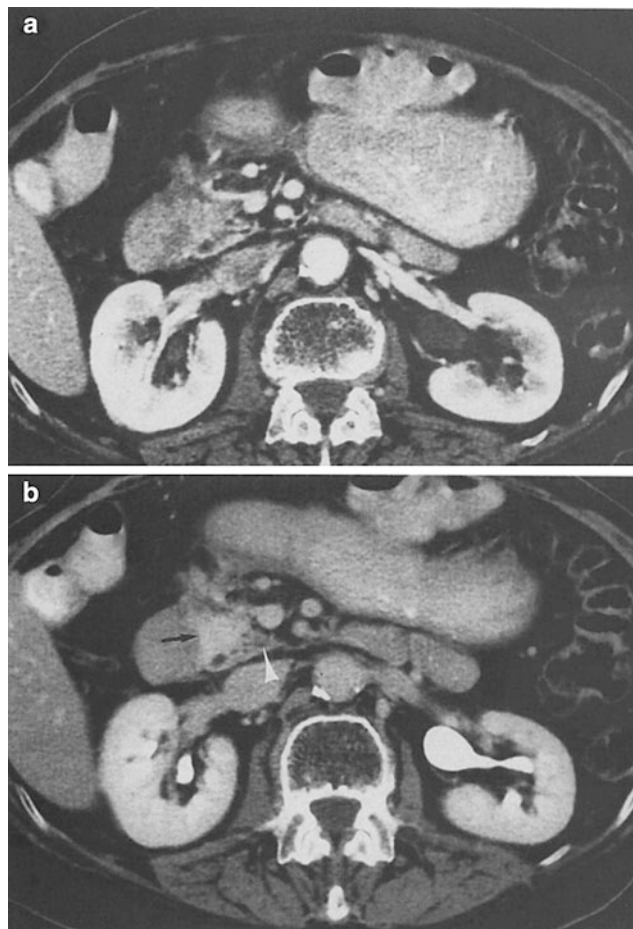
Diagnosis: This CT scan demonstrates postradiation changes 6 months after radiotherapy to the head of the pancreas in an asymptomatic patient with cholangiocarcinoma. a CT scan during the bolus phase of IV contrast enhancement shows normal enhancement of the head of the pancreas. b Delayed scan 4 min later shows abnormal hyperdense enhancement of the pancreatic head (*arrows*) that is indistinguishable from chronic pancreatitis. The uncinus process (*arrowhead*) is what the pancreatic head "should normally look like" on these 4 min delayed images. Computed tomography images courtesy of Chuslip Charnsangavej M.D., Department of Diagnostic Radiology, University of Texas, M.D. Anderson Cancer Center, Houston, TX
